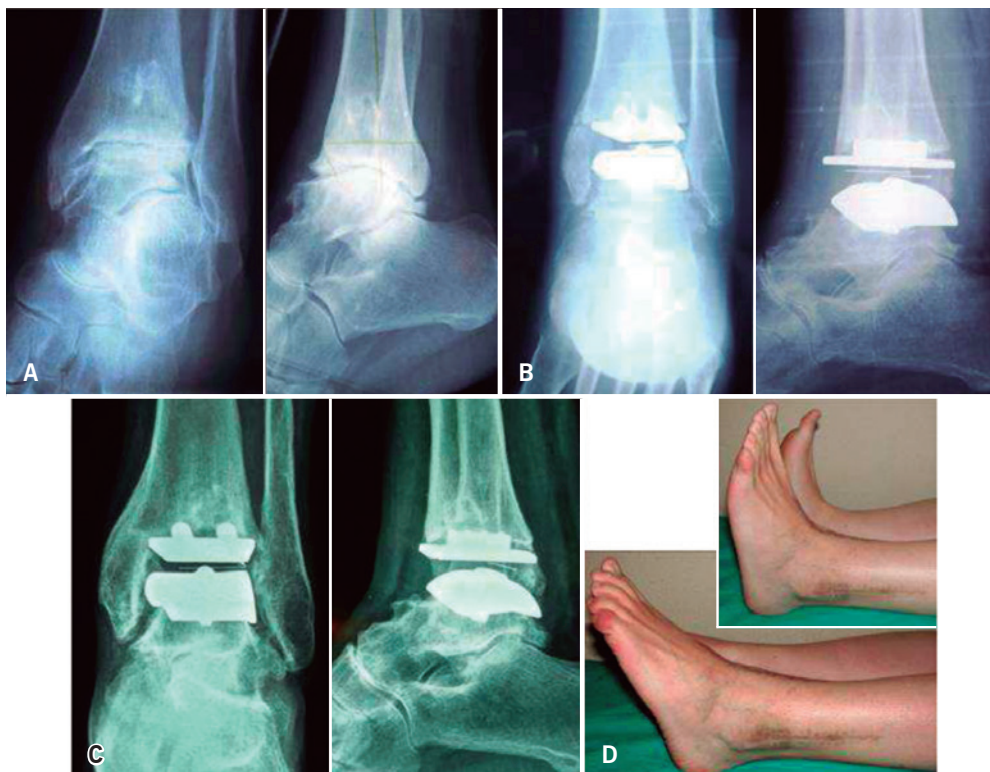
Male, 50 years old. Primary OA. Ramses II TAR. Stable, active life, no sports, occasional pain following long distance. A) Preoperative X-ray; B) postoperative X-ray; C) X-ray at 10 years. Radiolucent image under tibial component. Asymptomatic; D) Function
